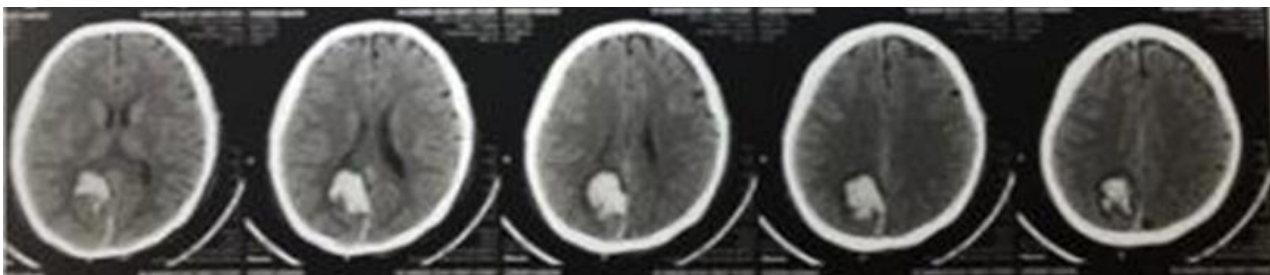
CT-Scan results at the previous examination.
